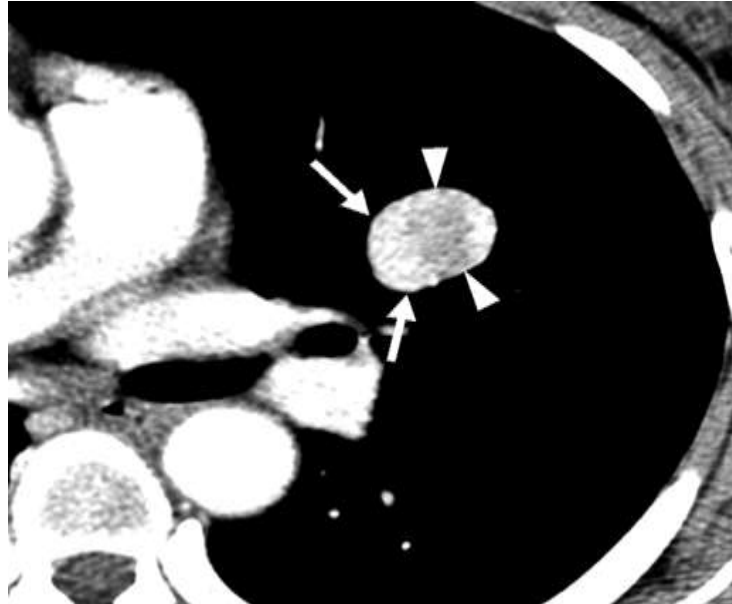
CT of the chest showing hemangioma
